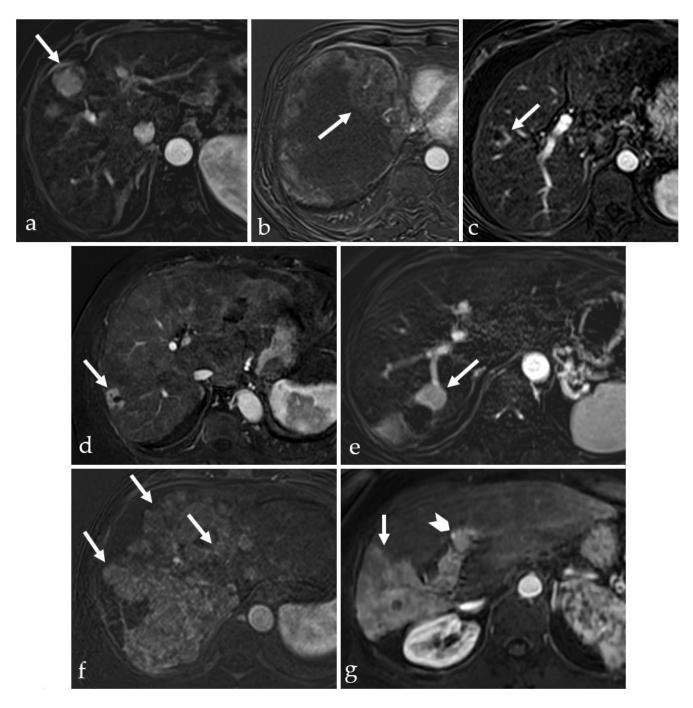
MRI axial images obtained by subtracting a T1 fat saturated image without contrast enhancement from a T1 fat saturated image with contrast enhancement in the arterial phase (a–g). Persistent/recurrent tumor tissue is hypervascular and can have different shapes: It can be similar to pretreatment (failure of treatment, arrow in (a)); Peripheral, inside the treated nodule (incomplete treatment, arrow in (b)); Crescent-shaped (arrow in (c)); Asymmetric ring (arrow in (d)); Nodular-shaped (arrow in (e)); Multinodular-shaped (arrows in (f)); or wedge-shaped (arrow in (g)) with vascular invasion (chevron in (g)).
